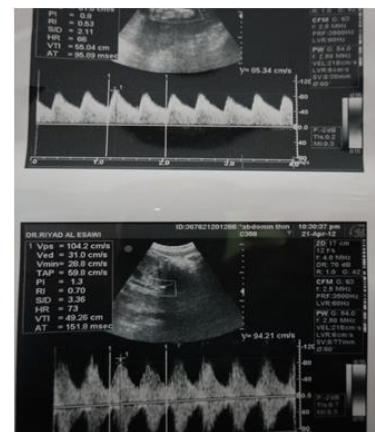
Doppler wave forms of AU (above) & Ao (below) at 38 weeks of gestation.
